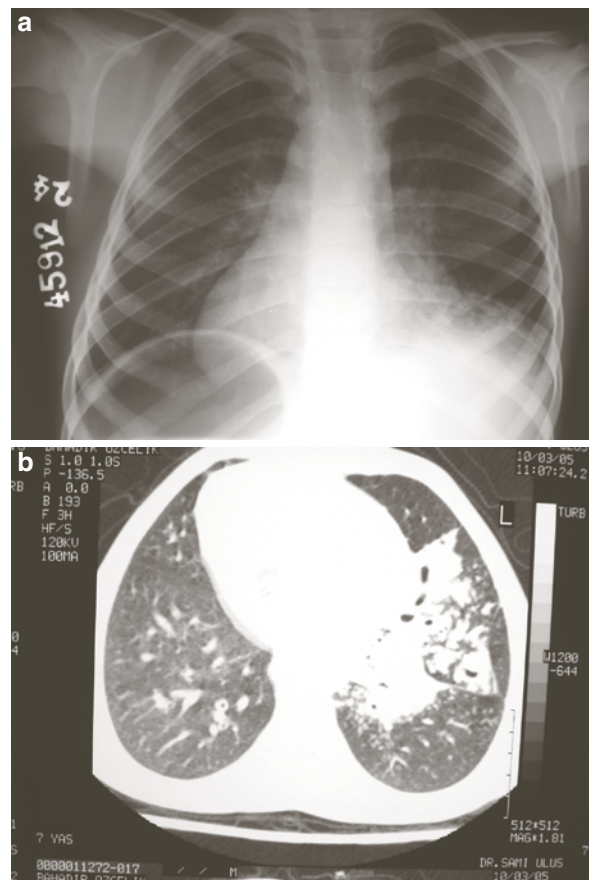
Kartagener syndrome, (a) dextrocardia on chest X-ray, (b) diffuse bronchiectasia on axial CT scan
